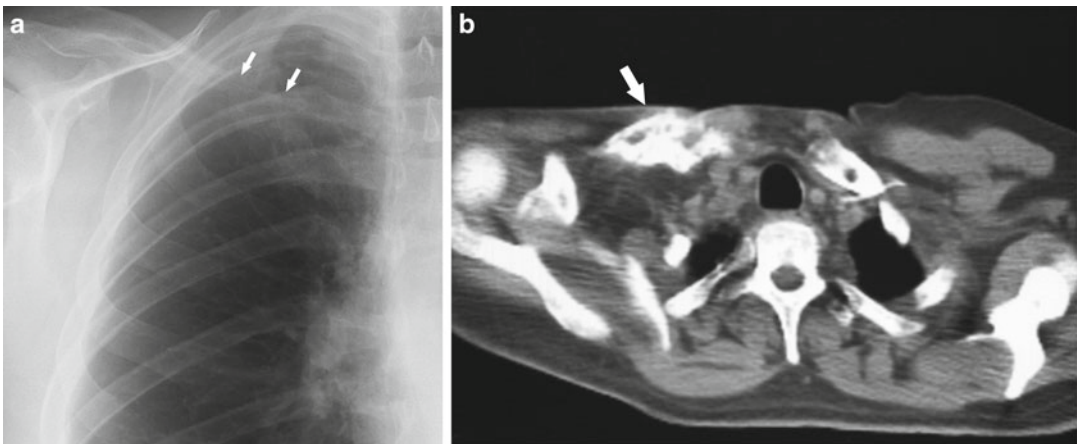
Osteosarcoma developing 20 years after radiation therapy for Hodgkin lymphoma. (a) Coned-down PA chest radiograph shows a lytic lesion in the mid right
